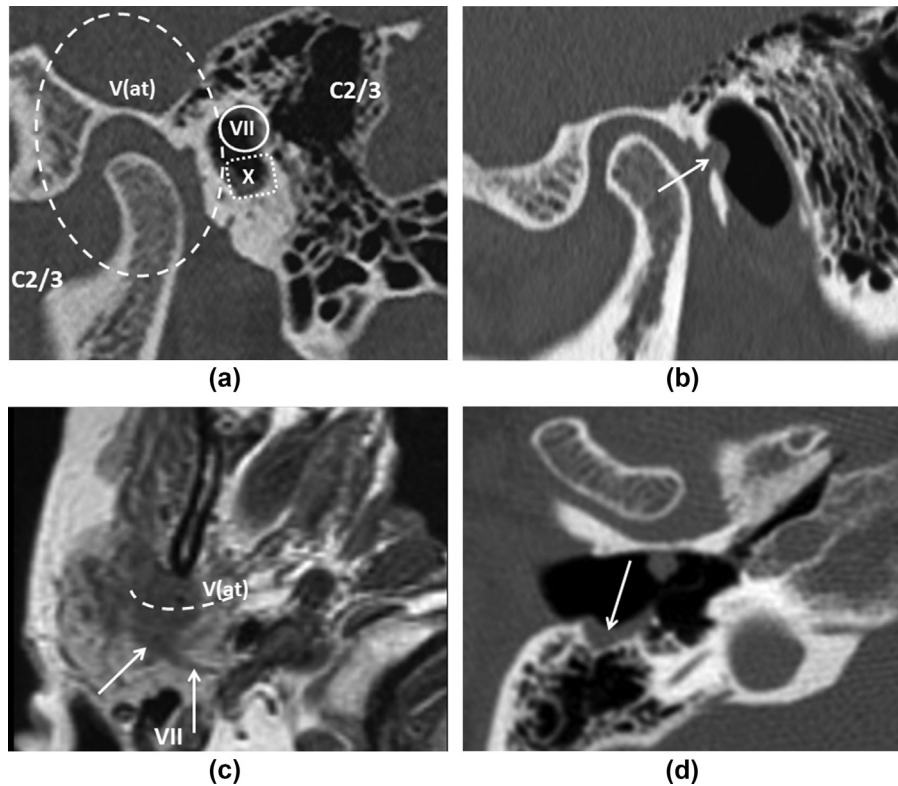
The TMJ and the ear. (a) Several cranial nerves (trigeminal: V, facial: VII, and vagus: X) innervate the external auditory canal (EAC) and the cervical plexus (C2/3) supplies the skin situated anteroinferior and posterior to the pinna. The auriculotemporal branch of the V nerve (V(at)) is the principal sensory supply to the TMJ, the anterior wall (tympanic plate) of the EAC, and skin situated anterosuperior to the pinna. The complex innervation of this region explains why it may be impossible, on clinical grounds, to distinguish between otalgia and pain originating in the TMJ or referred pain from other structures in the neck, pharynx or oral cavity innervated by the same cranial nerves or cervical plexus. (b) The patient presented with a sensation of irritation and noise in the ear, which was worse on chewing. Otoscopy demonstrated a small cyst along the anterior wall of the EAC, which changed in size with opening and closing the mouth. An oblique sagittal reconstruction from MDCT can showed focal protrusion of a “hernia” of the TMJ capsule via a developmental defect in the anterior wall of the tympanic plate (white arrow). (c) A middle-aged patient was investigated for pain, thought to be of TMJ origin, with CBCT (not shown); no abnormality was demonstrated. MRI was requested when pain progressed, there was paraesthesiae of skin situated anterior to the EAC and subtle facial (VII) nerve weakness. A T1-weighted axial MRI scan of the right parotid gland shows an irregular mass involving the auriculo-temporal nerve (V(at): white curved, dashed line) with perineural tumour spread along the right VII nerve (white arrows). Ultrasound-guided biopsy demonstrated undifferentiated carcinoma. (d) MDCT was requested by an oral medicine specialist for investigation of pain in the TMJ region without other symptoms of TMD. There is focal erosion of the posterior wall of the EAC on an axial, bone-window reconstruction of the right temporal bone from an MDCT scan. The defect is filled with soft-tissue, which represented cholesteatoma (white arrow). Focal debris was also present along the anterior wall of the EAC.
